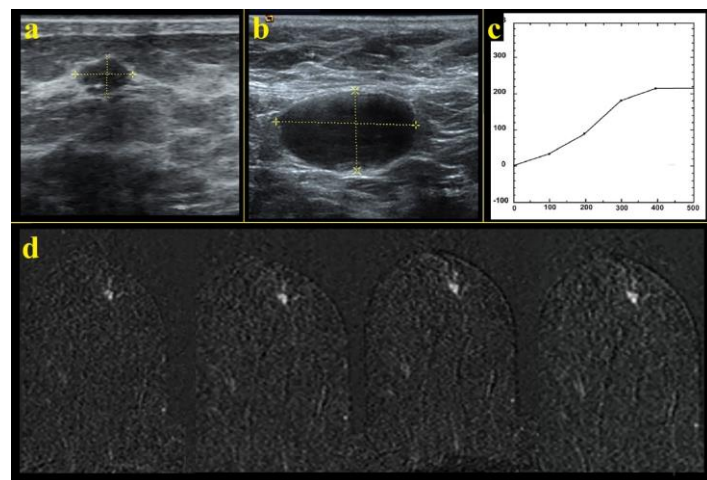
A 61-year-old female patient; an asymmetrically increased density in the retroareolar area of the right breast was found in routine follow-up mammography (MG). The patient was evaluated by ultrasonography (US), a: A solid lobulated contoured solid mass (BI-RADS category 4b) was detected in this region, b: In the ipsilateral axilla, a suspected lymphadenomegaly (LAM) was found, c: The lesion has a persistent enhancement (type 1 pattern) on time-contrast curve chart, d: Dynamic contrast T1W images showed the persistent enhancement of the lesion. Although the T2 hyperintensity and enhancement pattern indicate benignity, the lesion was accepted as BIRADS 4a due to the presence of axillary LAM. Biopsy was performed for suspicion of malignancy, and the lesion was reported as benign ductal hyperplasia and the axillary lymph node was reported as reactive lymphoid hyperplasia.
